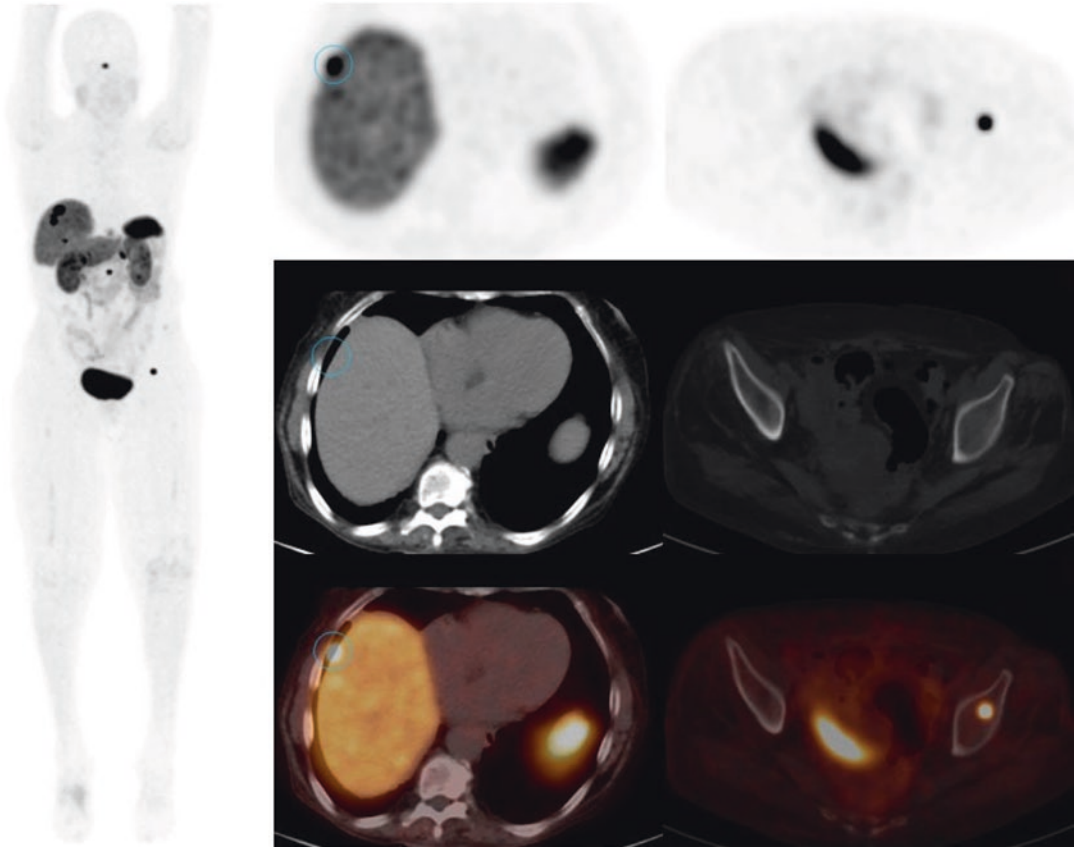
A 70-year old female with carcinoid tumor initially diagnosed in the small bowel. ^{64}Cu PET/CT demonstrates multiple foci of uptake in the liver (middle
